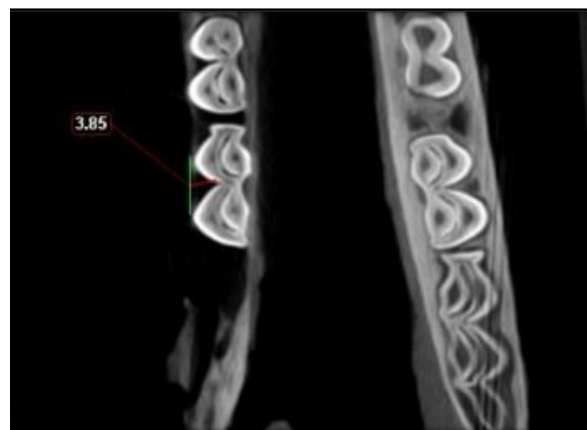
CBCT axial cut showing measurement of furcation bone loss: class II FI (3.85) mm class II horizontal bone destruction extending deeper than 2 mm but less than 6 mm into the furcation area.
